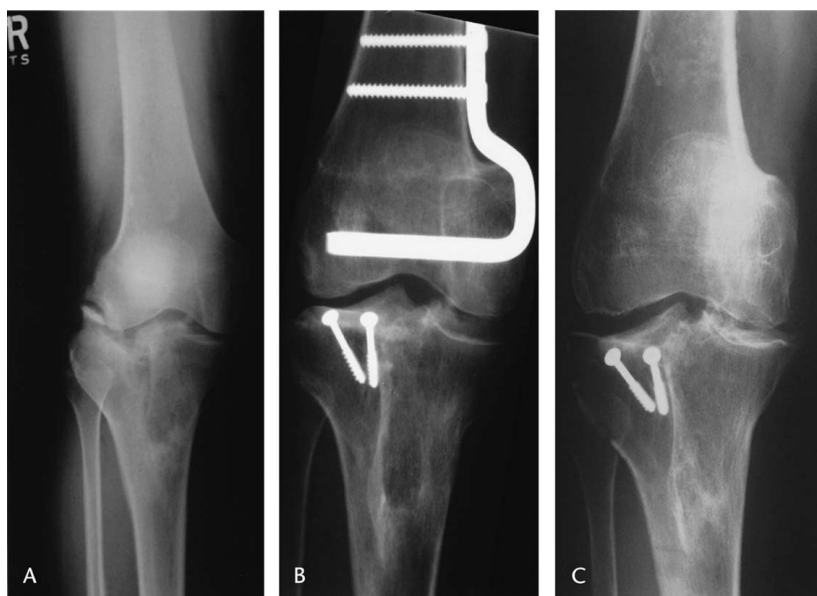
(A) An AP xray of a 30-year-old woman with a fracture of the lateral tibial plateau of her right knee is shown 2 years after initial internal fixation. The hardware has been removed. (B) An AP xray 6 months after reconstruction with fresh lateral plateau allograft done in conjunction with distal femoral varus osteotomy is shown. (C) An AP xray 12 years after reconstruction shows the plateau graft and lateral compartment joint space are well maintained but the medial compartment shows degenerative changes.
